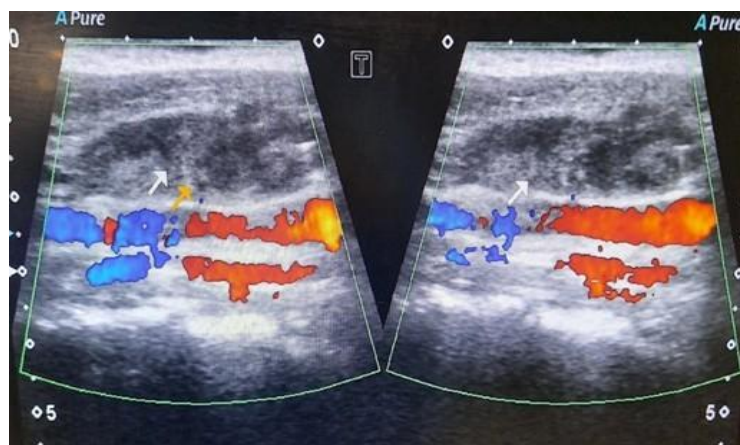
Figure IV ultrasound neck demonstrating embolization material with the pseudo-aneurysm with its complete occlusion
